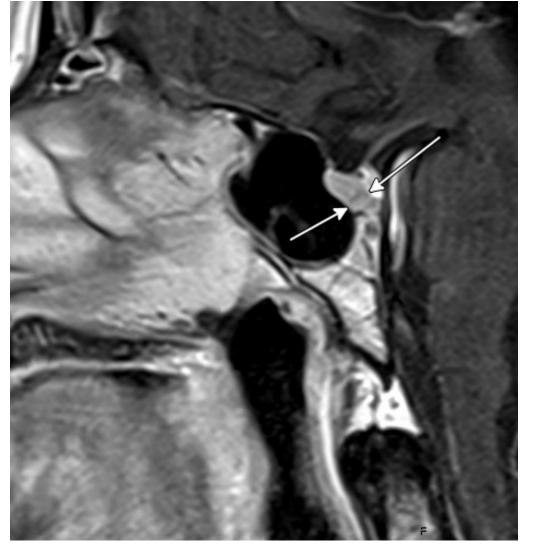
A 3.6 mm pituitary microadenoma (white arrows) on contrast-enhanced MRI
